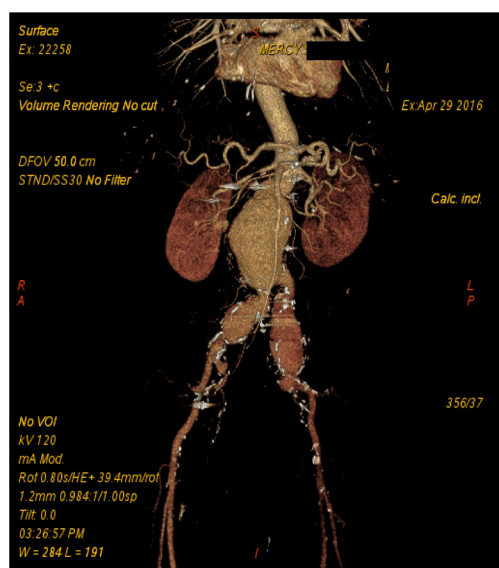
Showing the CT angiogram of the abdominal vessels demonstrating the abdominal aortic aneurysm and its close relation to the biliary system. The aneurysmal dilation of iliac arteries can be seen too.
